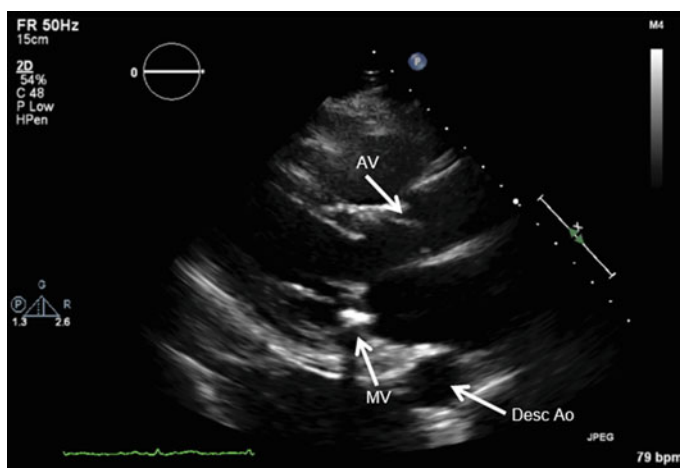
Parasternal LAX view (increased depth). *AV* aortic valve; *MV* mitral valve; *Desc Ao* descending aorta
